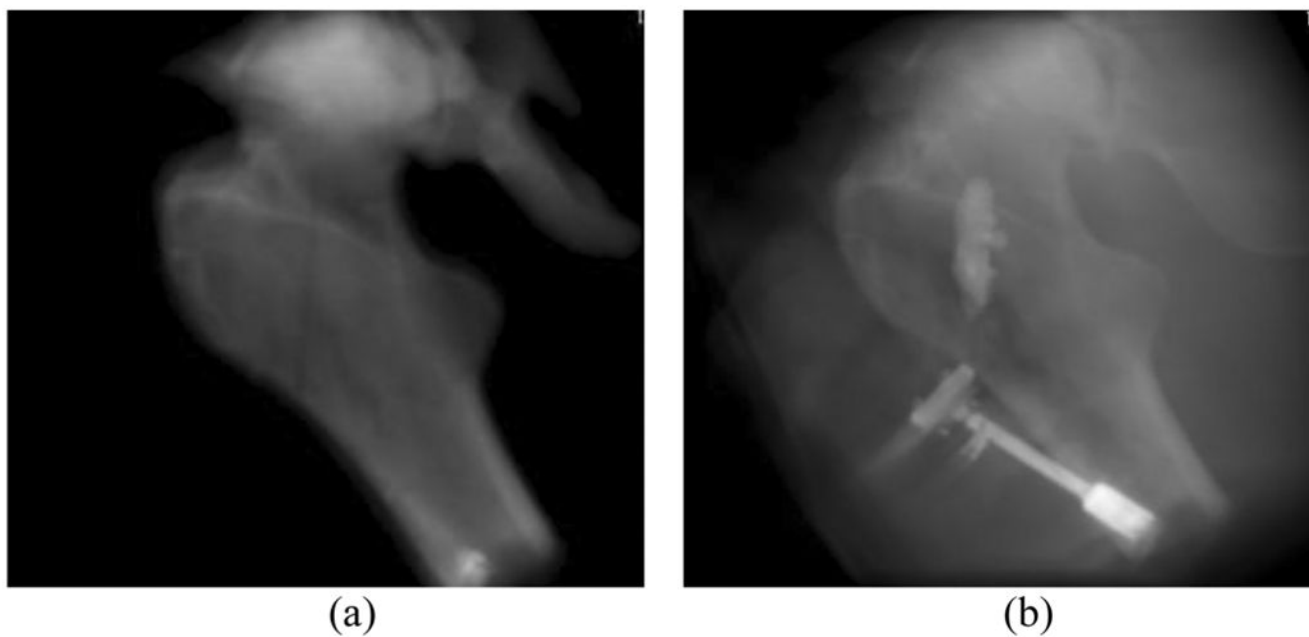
Synthesized (a) pre-operative X-ray image of dry femur and (b) postoperative X-ray image with cement attenuation of 1900 HU.
